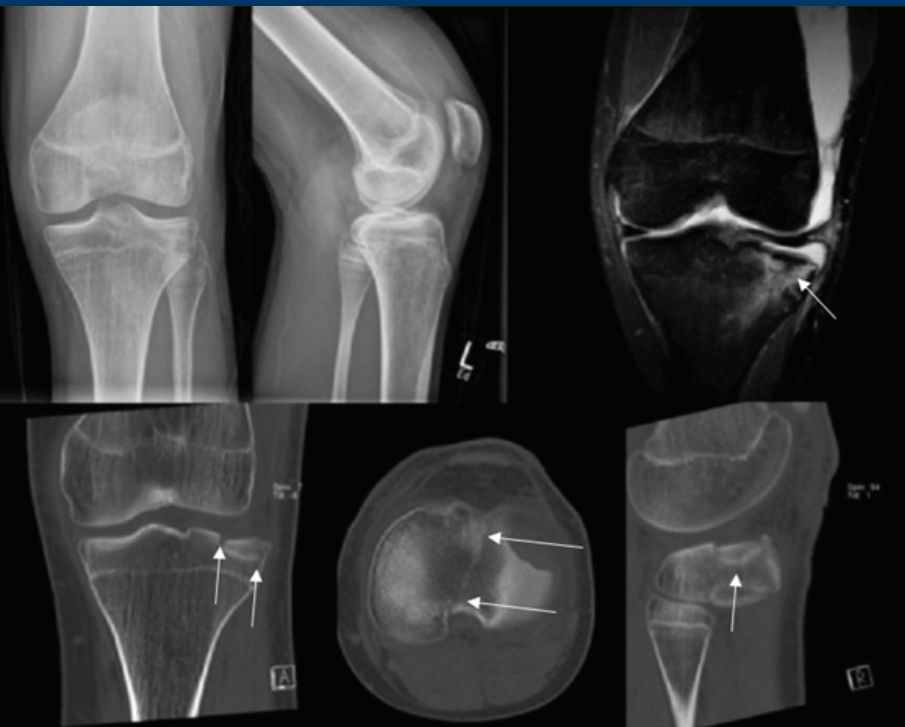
16 yo male with knee pain after sports injury. Top left: frontal and lateral knee X-rays exhibiting a knee joint effusion and proximal fibula cortical irregularity. Bottom row from left to right: Coronal, axial and sagittal knee CT in bone windows depicting the depressed lateral tibial plateau (LTP) acute fracture extending through tibial spine. Top Right: fluid sensitive coronal sequence MRI knee demonstrating the marrow oedema and chondral fracture associated with the depressed LTP fragment and consequent articular surface irregularity which was subsequently surgically corrected to mitigate risk of acceleration osteoarthritis.
